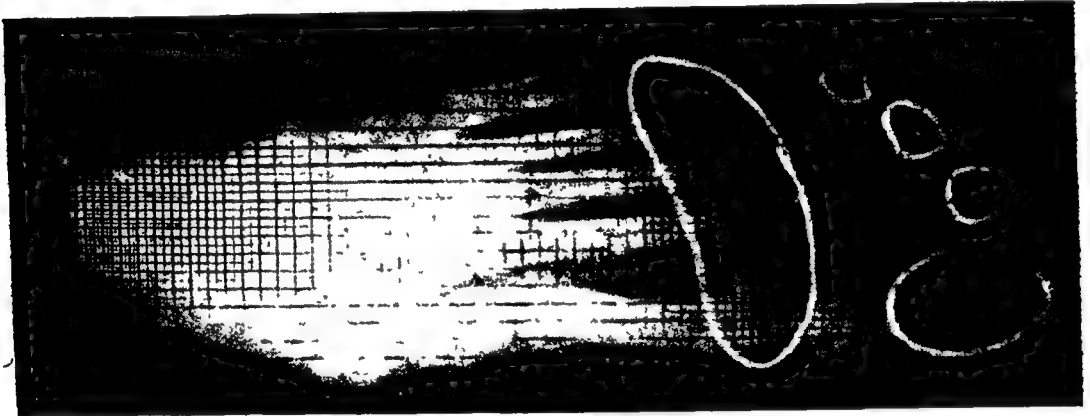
ORTHODYNAMIC RADIOGRAPH (X-RAY PAPER). Muscular dystrophy case. imprint for all toes and metatarsophalangeal joints indicates balancing and propulsive effort
